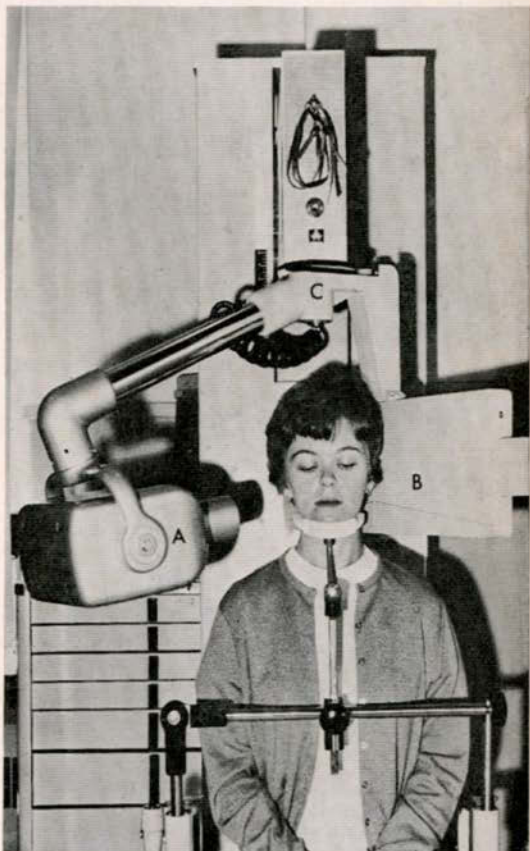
The Panorex Panoramic Radiographic Machine
